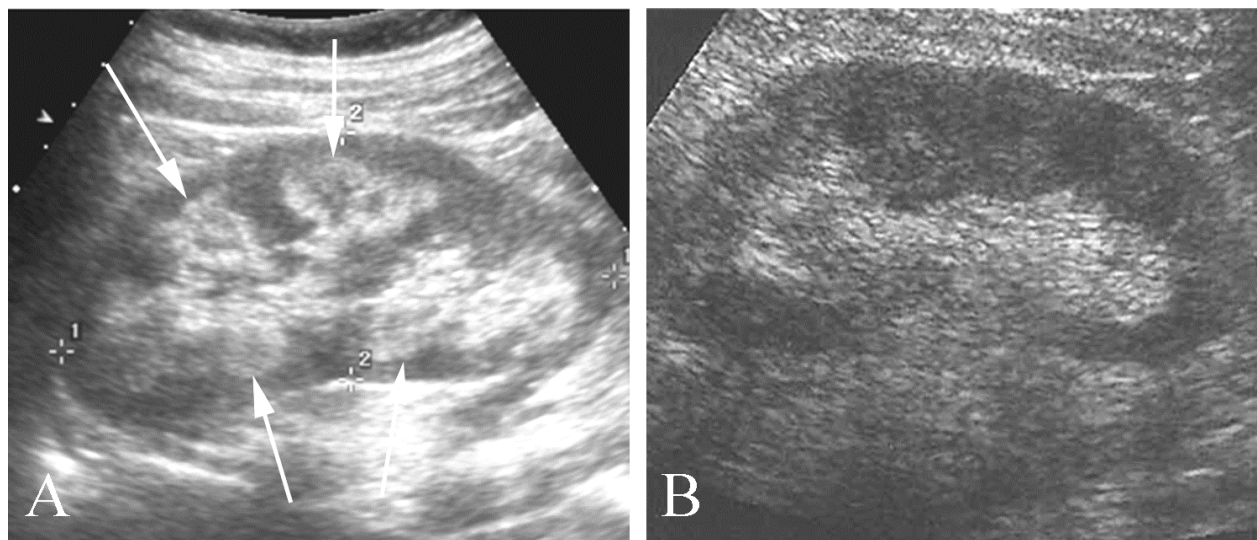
Medullary sponge kidney in a 30 year old pregnant woman with hematuria. A. Renal ultrasound of the patient shows marked increase in renal echogenicity extending through the renal cortex (arrows), indicating medullary sponge kidney. B. A normal kidney for comparison. Note the increased echoes are confined to the central portion of the kidney in the renal pelvis.
